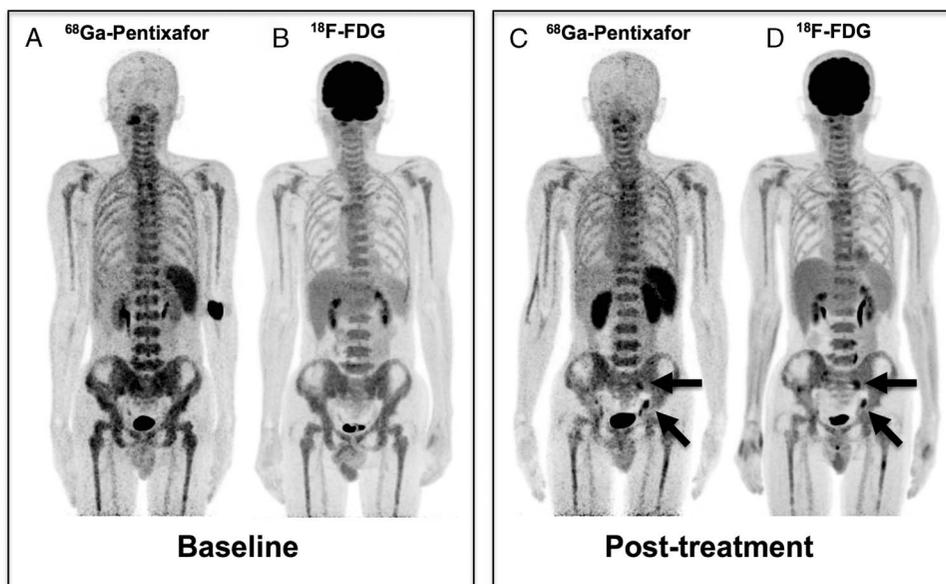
Patient 15 (male, 64 years, intermediate risk of ISS-WM) with clinically PD after 5 cycles of chlorambucil. At baseline, ⁶⁸Ga-pentixafor (A) and ¹⁸F-FDG (B) PET/CT showed increased uptake in bone marrow without extramedullary involvement. After chemotherapy, there were emerging lesions involving bilateral iliac lymph nodes in both ⁶⁸Ga-pentixafor (C, arrows) and ¹⁸F-FDG PET/CT (D, arrows), whereas the bone marrow uptake of both ⁶⁸Ga-pentixafor and ¹⁸F-FDG remained unchanged.
